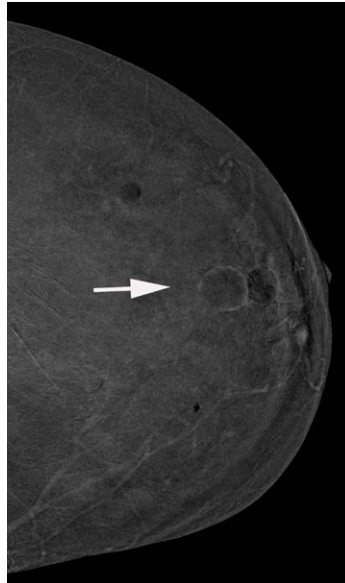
MASS INTERNAL ENHANCEMENT: RIM: Rim enhancement on RC image (arrow). Pathology: none. Simple cyst by ultrasound.
